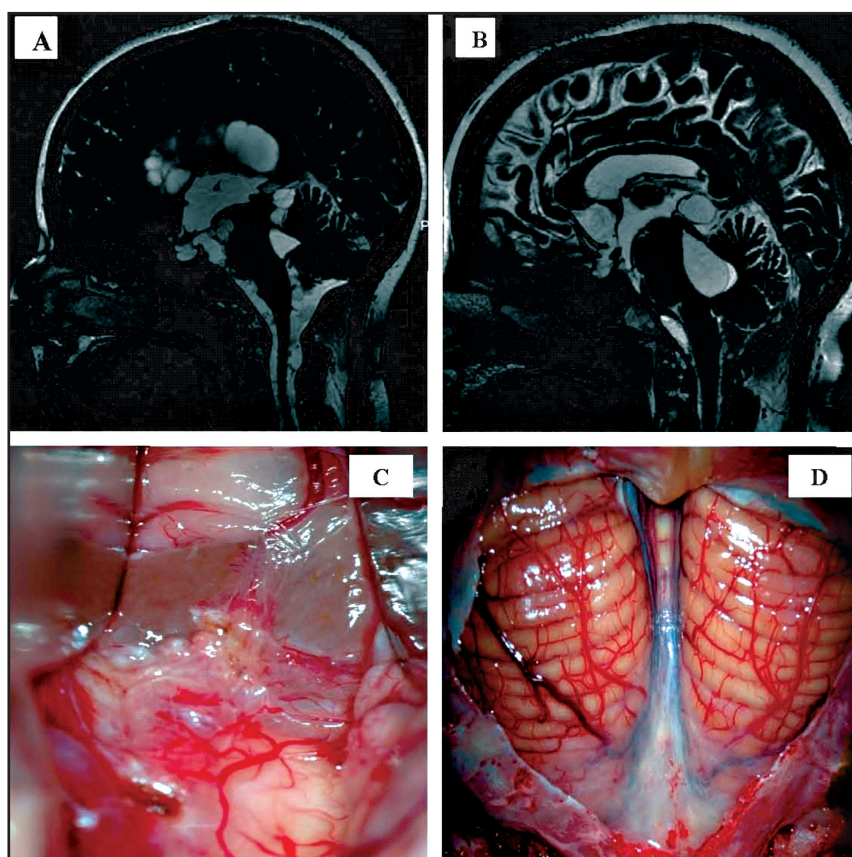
A - Sagittal magnetic resonance Imaging (MRI) with a fast imaging employing steady state acquisition (FIESTA) acquisition demonstrating inflammatory granulomatosis, arachnoiditis and cystic lesions inside the lateral ventricles, third ventricle, pineal region and basal cisterns. B - T2 weighted sagittal MRI showing a large cyst inside the fourth ventricle and in the pineal region and cysts in the basal cisterns. C, D - Surgical approach. In D the cerebellum with cisterna magna intact demonstrating arachnoiditis in this region. In C after opening of the cisterna magna and spatulation of the cerebellum hemispheres in the middle line also showing arachnoiditis. In C the surgeon is approaching the fourth ventricle.
